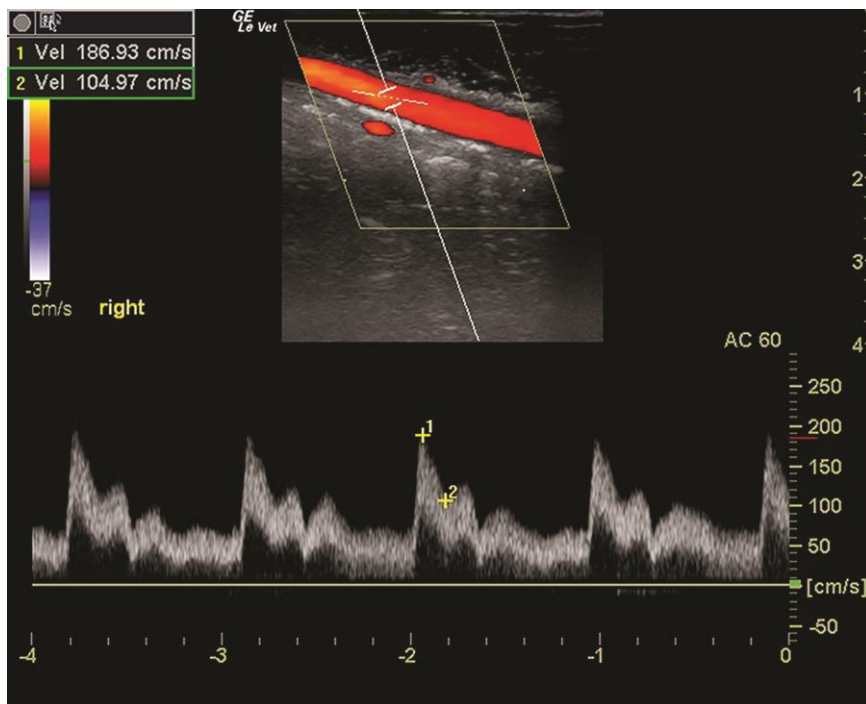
Ultrasound image of the GCVP at 9 weeks showing the pulsatile flow through the artery as well as the measurement of the systolic and diastolic flow rates. There was no vessel occlusion seen on any of the arteries at any time point. The flow rates were analyzed and there was no significant difference between control and experimental patches.
